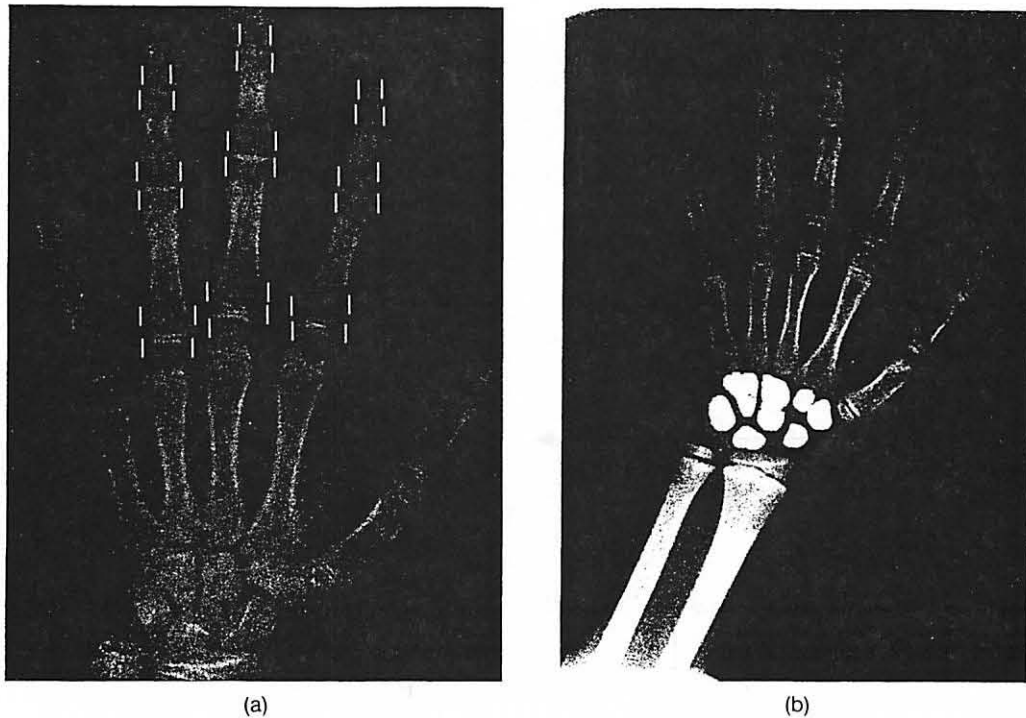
CR hand wrist image with (a) automatically extracted diameters, marked on the II, III, and IV phalanx; and (b) automatically extracted carpal bones superimposed on a hand radiograph.
